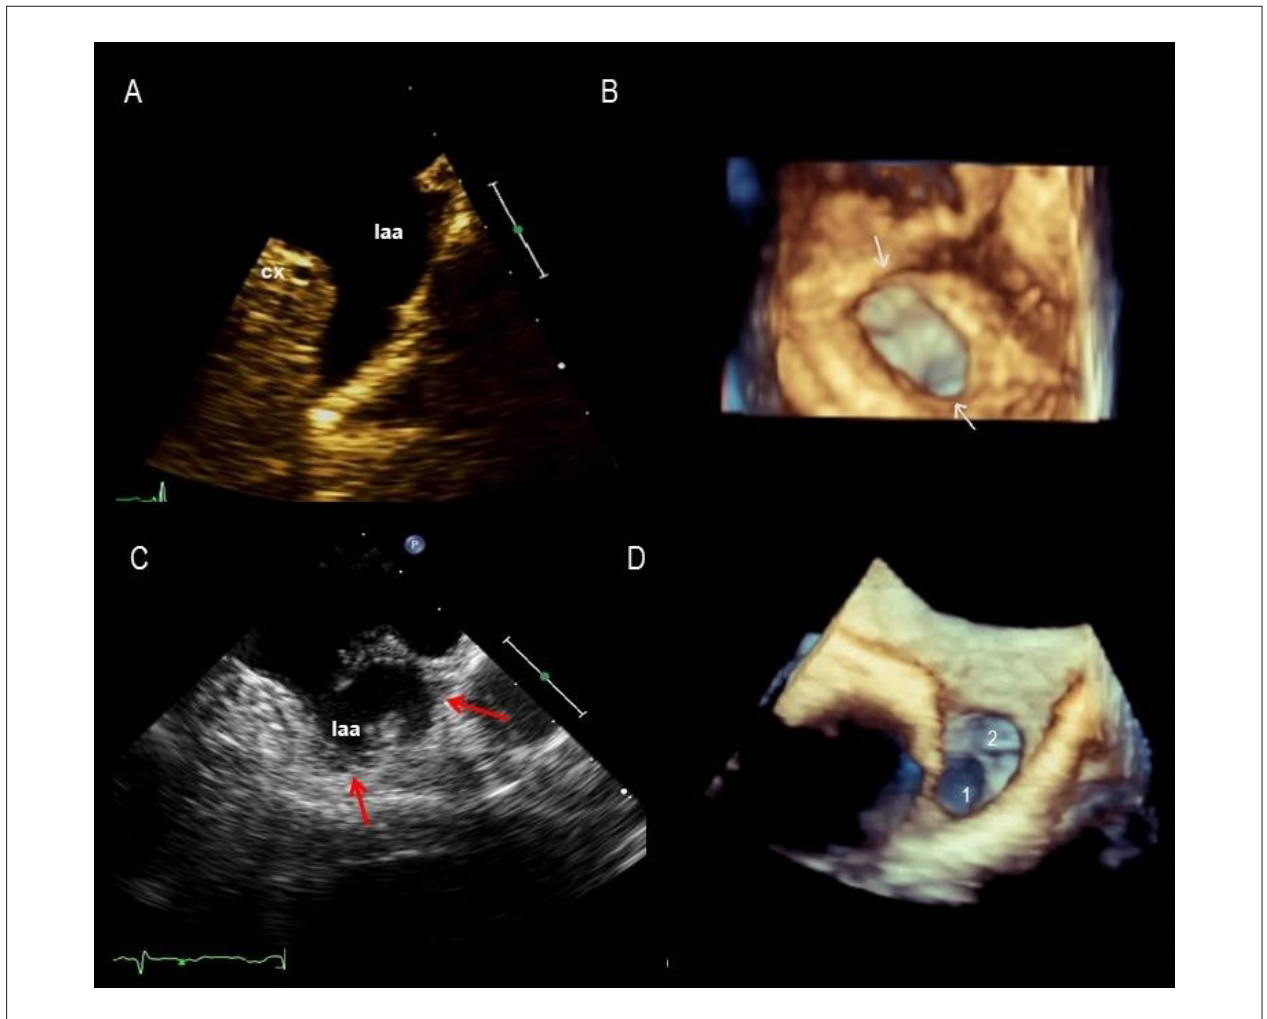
Evaluation of Left Atrial Appendage (LAA) by two-dimensional (2D) and three-dimensional (3D) Transesophageal Echocardiography (TEE). A: 2D TEE shows usual aspect of single lobe LAA free of thrombi, and its relationship with the circumflex artery (cx); B: 3D TEE of the same individual with en face view of the oval orifice (white arrows) and cul-de-sac view; C: 2D TEE shows two lobe LAA (red arrows); D: 3D TEE reveals two different culs-de-sac distinct, free of thrombi.
